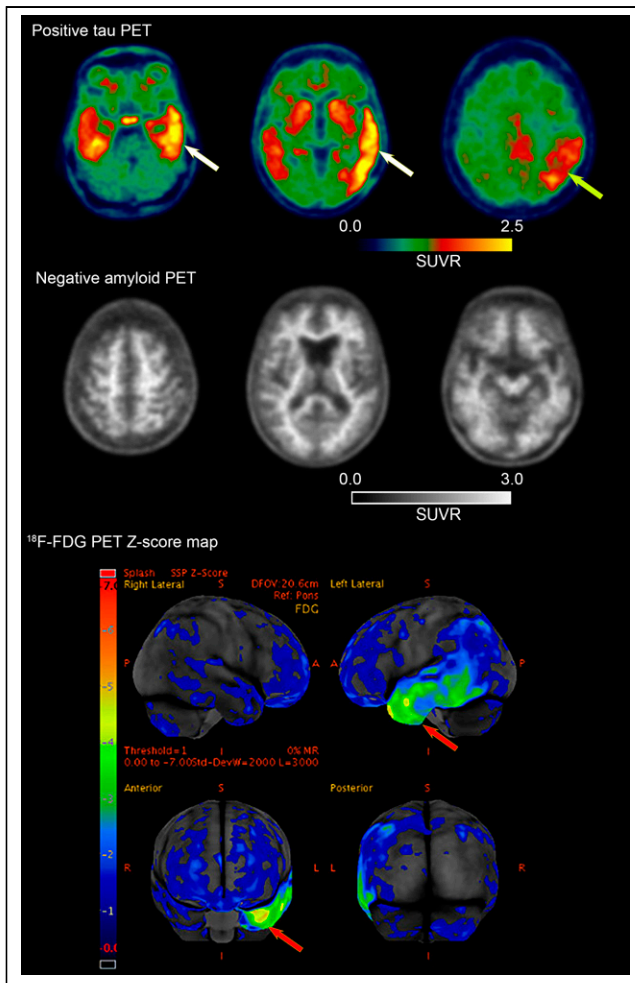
Positive tau PET in semantic dementia. (Top row) Multiple PET examinations from patient with semantic dementia, commonly with underlying TDP-43 proteinopathy. ^{18}F -flortaucipir PET was positive, more prominently in left than right temporal lobes (white arrows) and left parietal lobe (yellow arrow). (Second row) ^{11}C -PiB PET was negative, with preserved gray–white contrast indicating lack of moderate or frequent amyloid- β neuritic plaques. (Third and fourth rows) ^{18}F -FDG PET z score maps demonstrated regions of hypometabolism correlating with tau PET, worst in left anterior temporal lobe (arrows). Pattern of hypometabolism is characteristic of semantic dementia. Although tau PET was positive, which can be seen with AD, alternative neurodegenerative entities can also result in abnormal tau PET. In this case, negative amyloid PET and pattern of ^{18}F -FDG hypometabolism suggest semantic dementia. SUVR = SUV ratio.
